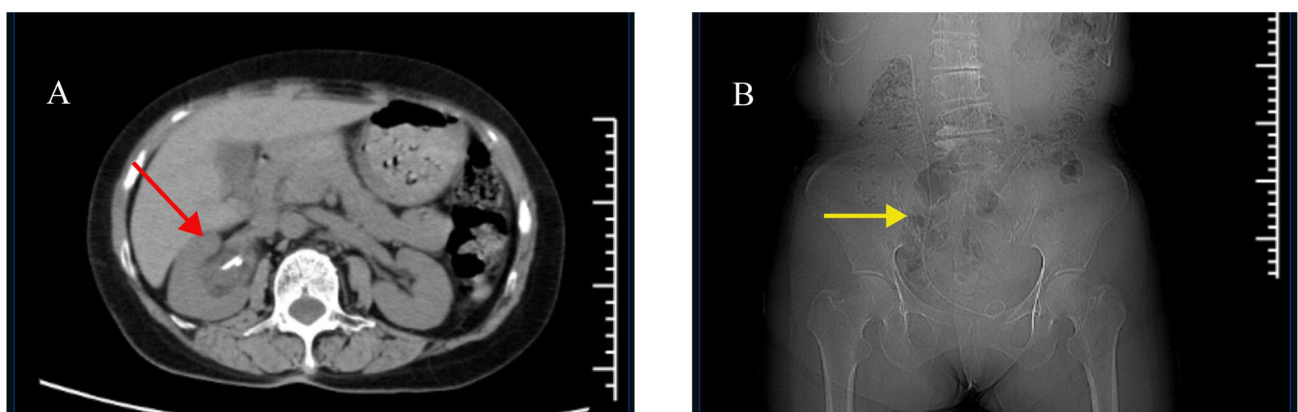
Postoperative imaging evaluation before double-J stent removal. (A) Axial CT scan showing the right kidney. The red arrow indicates mild persistent dilation of the right renal pelvis, which represented improvement compared to the preoperative right hydronephrosis, with no evidence of new or high-grade obstruction. (B) CT scout view (topogram) demonstrating the stable and correct position of the indwelling right ureteral stent (yellow arrow) prior to its planned removal.
